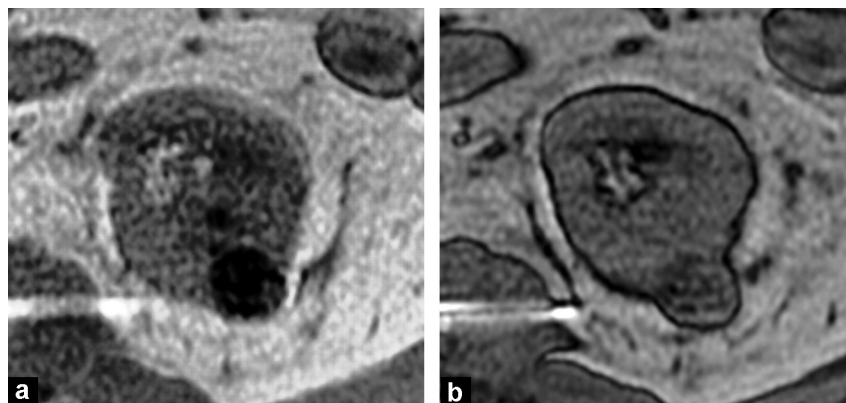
Papillary carcinoma with reduced in phase signal; a: MRI: in phase image; b: MRI: out of phase image.
